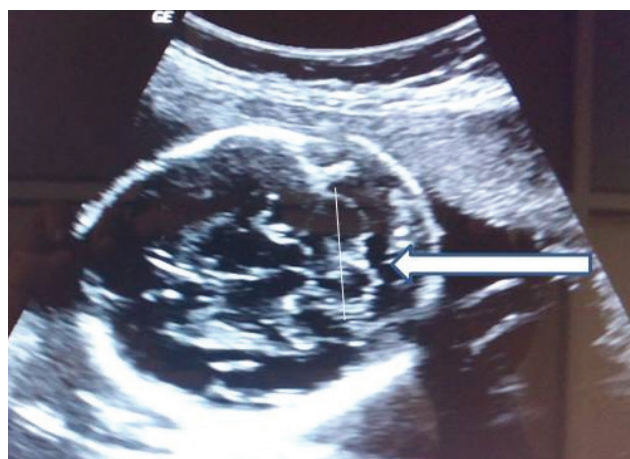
Ultrasonographic image showing TCD measurement (Arrow)
